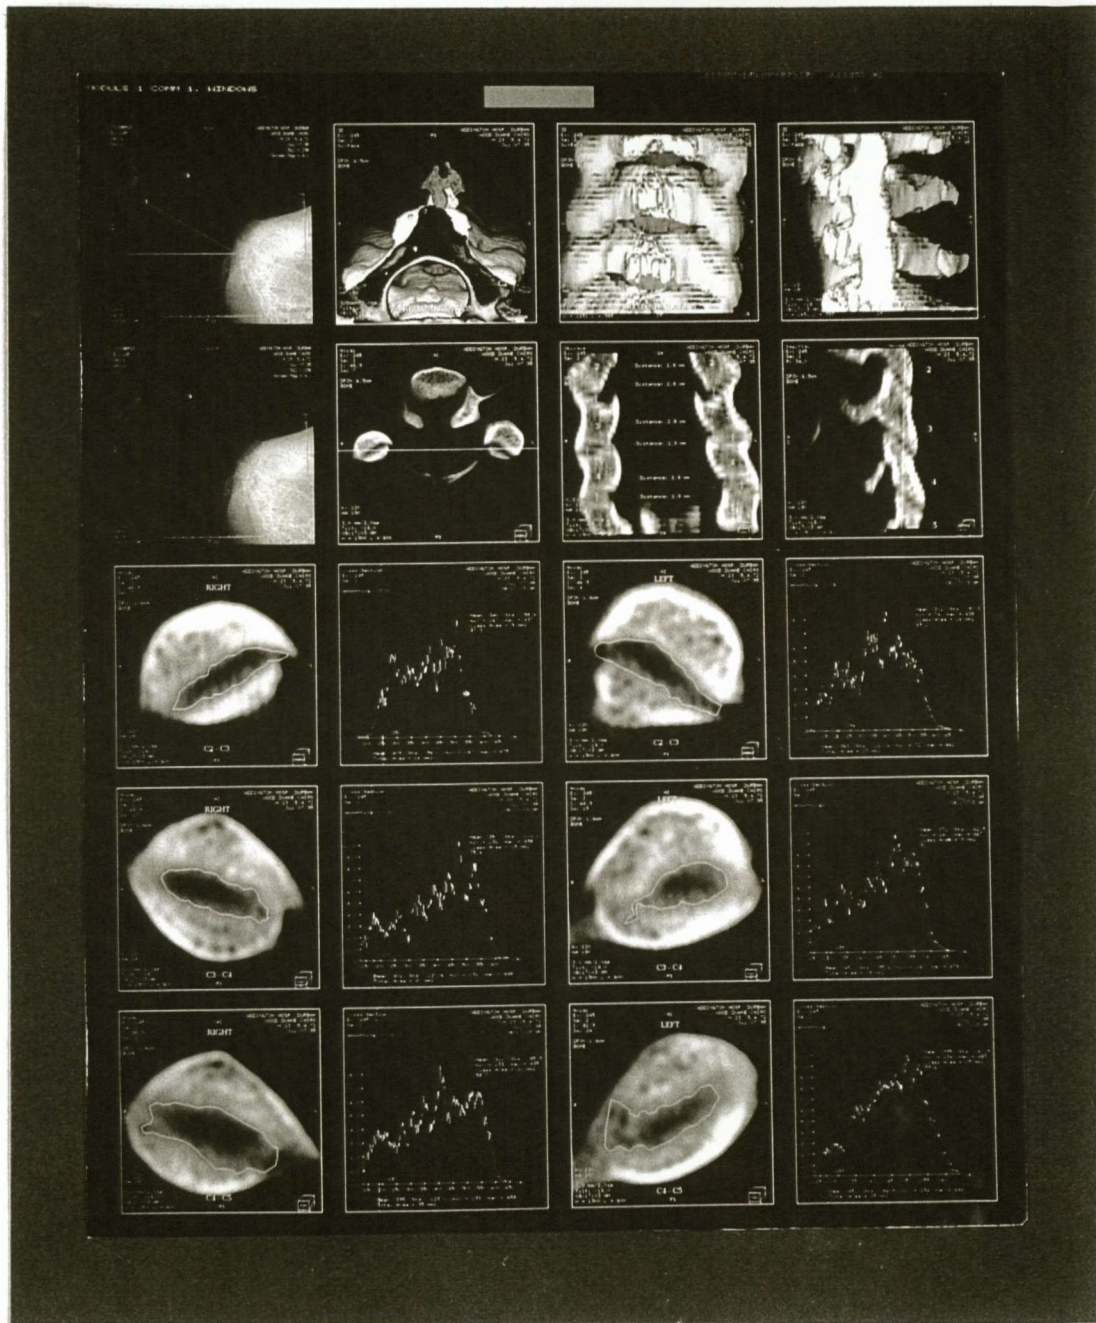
Experiment 4 : Pre-manipulation + 8kg traction CT scan
